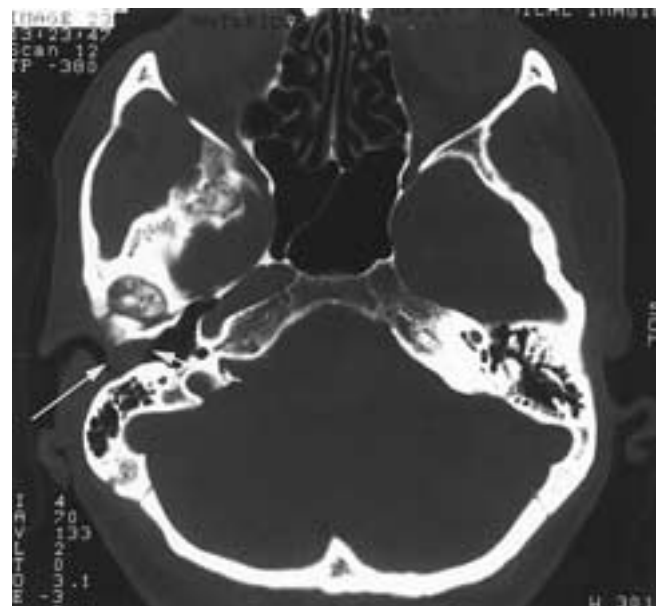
Synovial cyst. Axial CT scan of a patient with a 1 cm synovial cyst (*arrows*) extending into the external auditory canal. There are extensive degenerative changes of the condyle head. At surgery the cyst was found to extend into the joint through the bony fissure.
